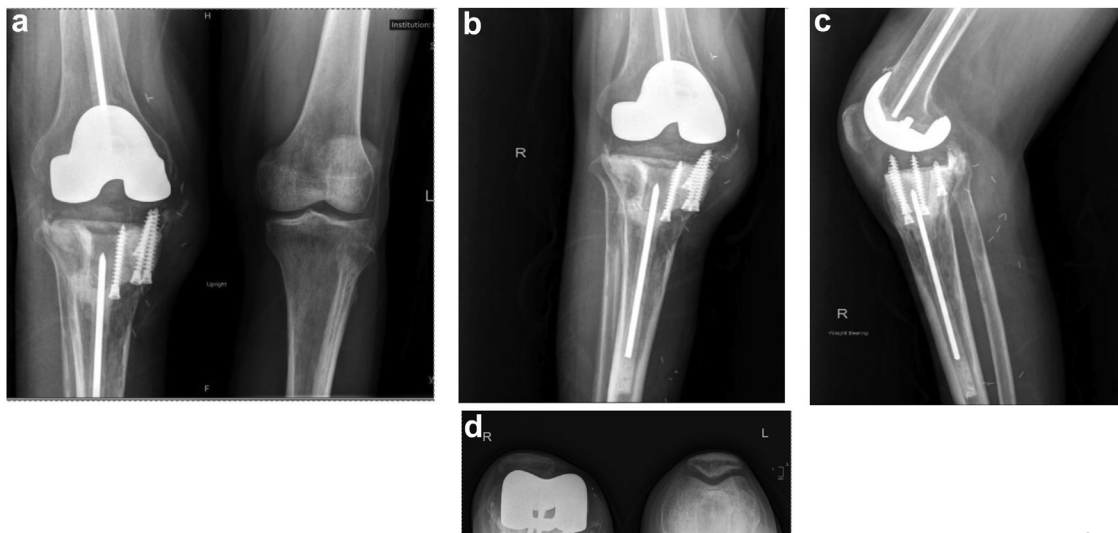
Eight-month postoperative radiographs. (a) Bilateral weight bearing Anteroposterior; (b) Anteroposterior; (c) Lateral; (d) Sunrise view demonstrating well-aligned components in a good position—no lucencies, fractures, or dislocations.
